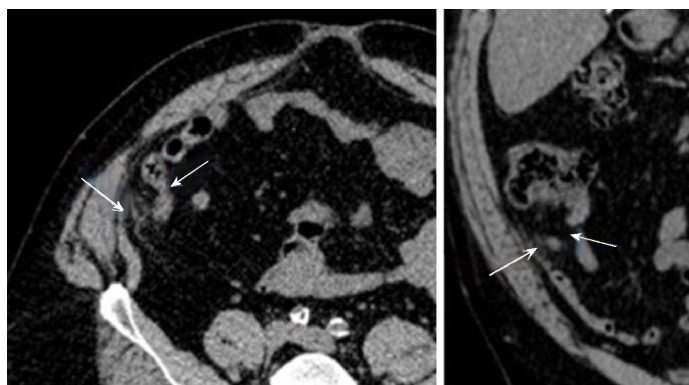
Abdominal computed tomography scan. A 1.0 cm × 1.8 cm focus of oval inflammatory changes surrounding central fat density visualized adjacent to the tip of the appendix and inferior aspect of the cecum noted. This is likely due to epiploic appendagitis. Possibility of very early acute distal tip appendicitis cannot be entirely excluded but felt to be less likely (Short arrow: Appendix; Long arrow: Epiploic appendagitis).
